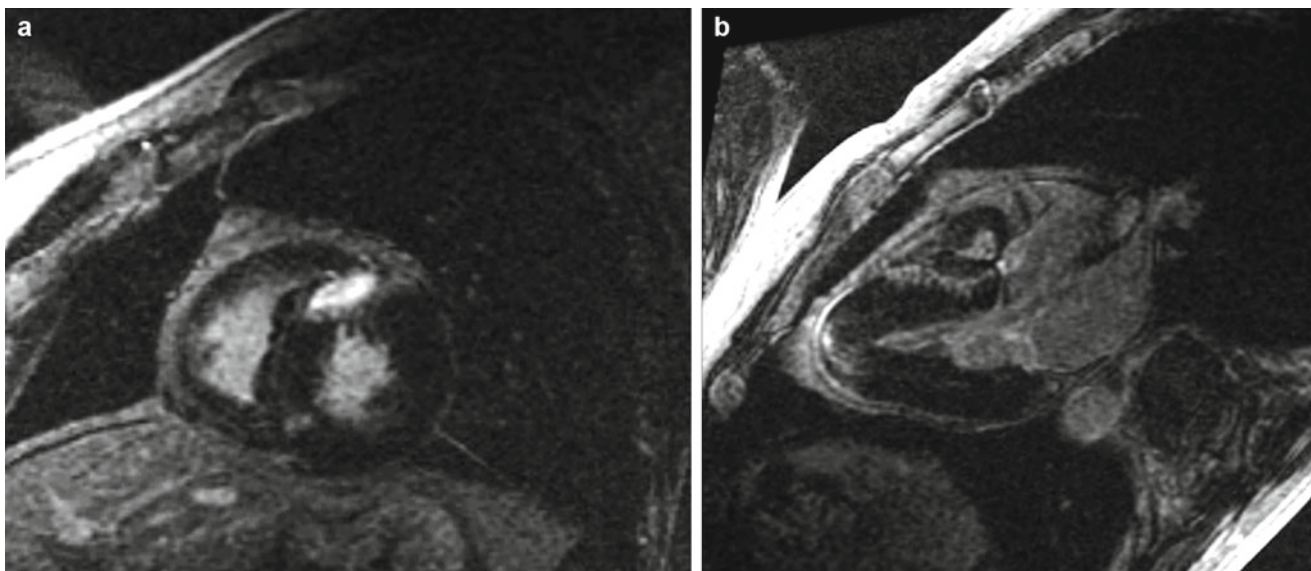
DE-MRI images of a 55-year-old female with a history of ventricular tachycardia. Workup included a normal cardiac catheterization, mildly dilated left ventricle with an ejection fraction of 50%, and a biopsy of the right ventricle which was unrevealing. (a and b)
